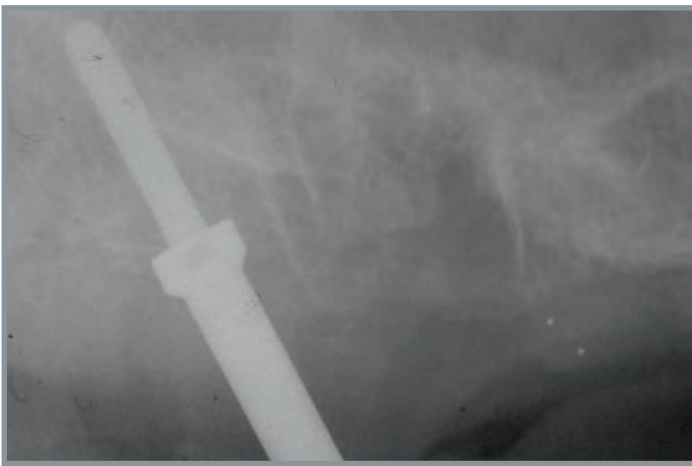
Periapical intraoperative radiograph. The axis obtained with the initial drill is corrected.
